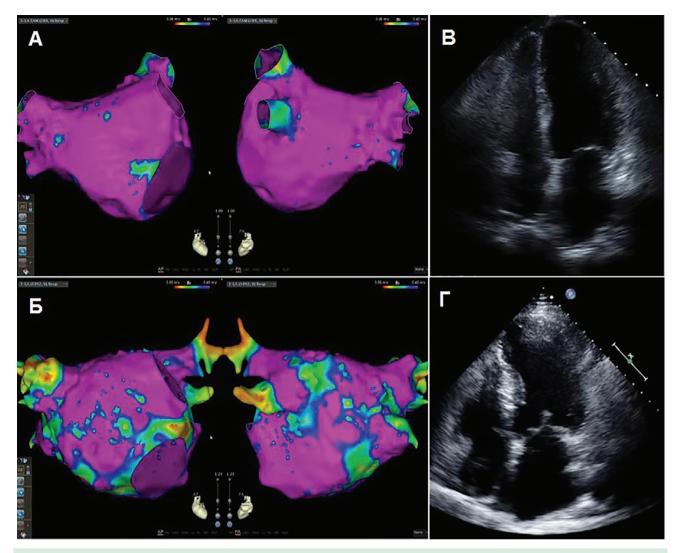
Bipolar stress maps and echocardiographic data in patients with hypertrophic cardiomyopathy and atrial fibrillation
